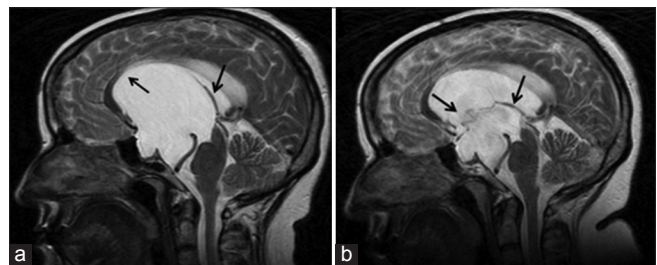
Case 2. (a) Preoperative magnetic resonance imaging (MRI): The sagittal plane T2-weighted image shows the enormous cyst (arrows) displacing the corpus callosum (CC) and the brain-stem. (b) The corresponding postoperative MRI: After treatment the deflated cyst wall is visible (arrows) and the CC with internal cerebral veins as well as the brain-stem appear decompressed
